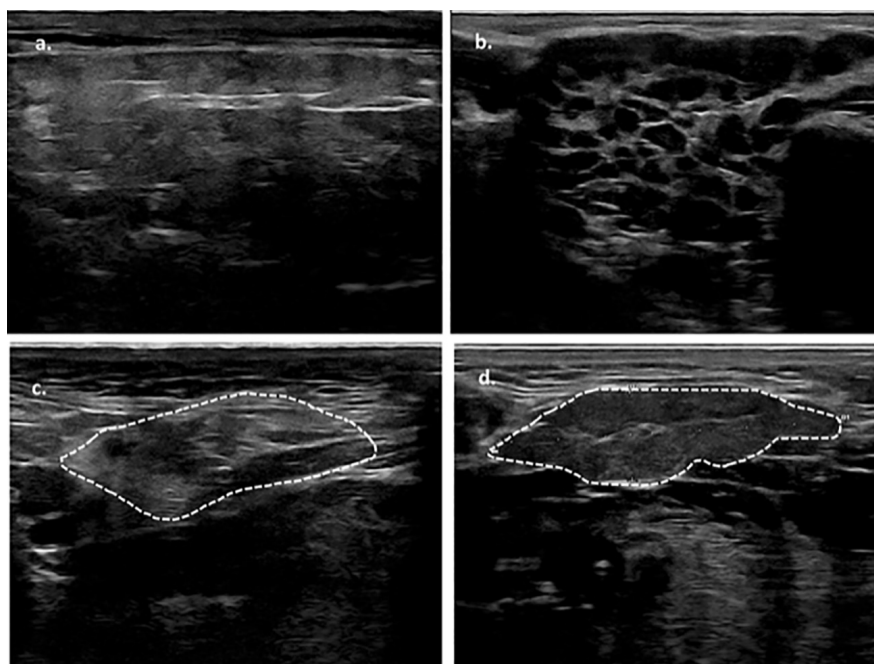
Ultrasonographic images of the major salivary glands of patients with systemic diseases who had positive ultrasound for SjD: a. parotid gland of patient with HIV infection; b. parotid gland of patient with sarcoidosis; c. submandibular gland of patient with HIV infection; d. submandibular gland of patient with sarcoidosis.
